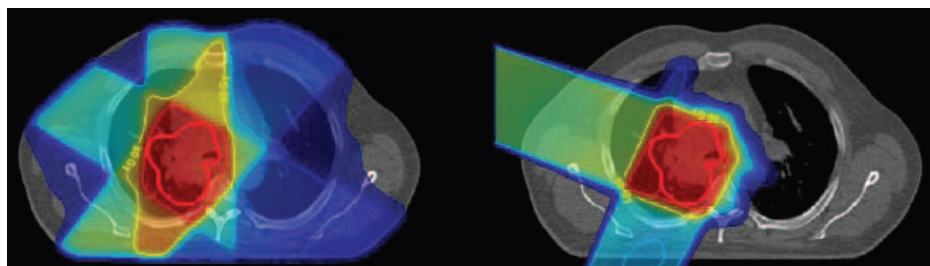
Comparison of dose color-wash display superimposed onto a grey-scale CT of photon (left) and proton (right) treatment plans. The target is marked with a red line. The isodose areas are 1, 10, 25, 50 and 67 Gy ranging from dark blue to red where dark blue is 1 Gy and red is 67 Gy (Roelofs et al., 2012).
